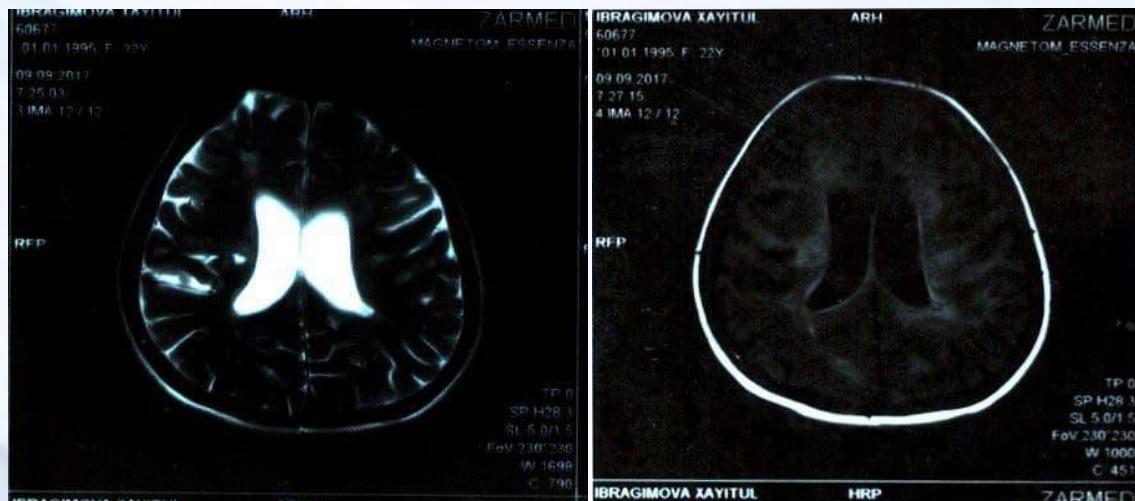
MRI. B-oh, 52, MRI of the brain with a diagnosis of DEG
